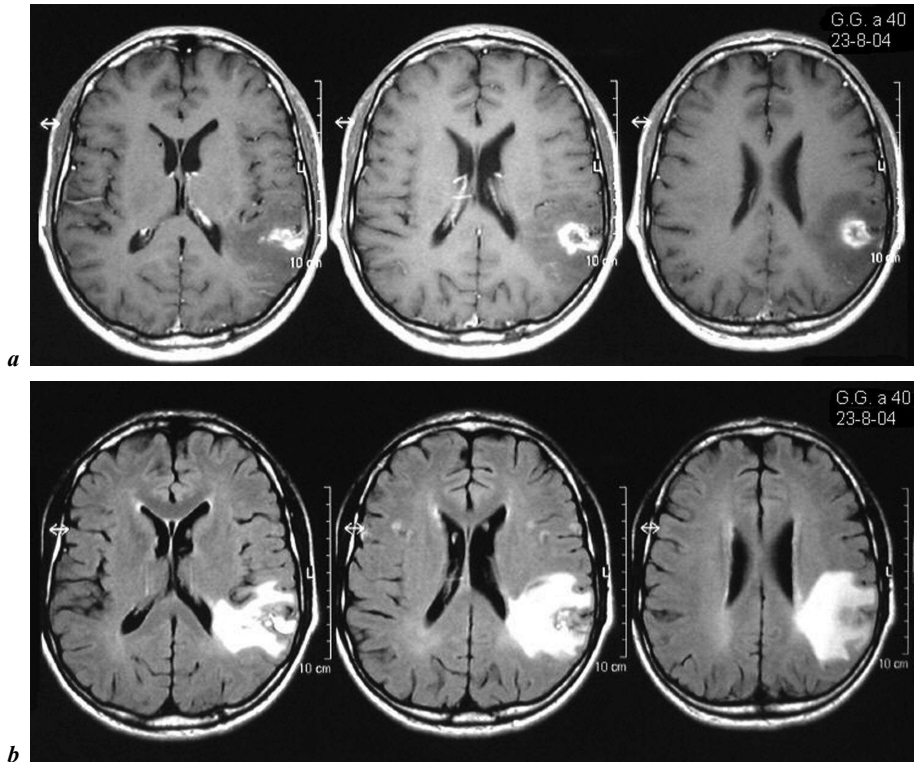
a, b Same patient of figure 2. Eight months after radiosurgery. Dysphasia and difficulty with calculation. MRI imaging showing contrast enhanced area, surrounded by edema. Clinical picture normalized after 15 days corticoid medication.
